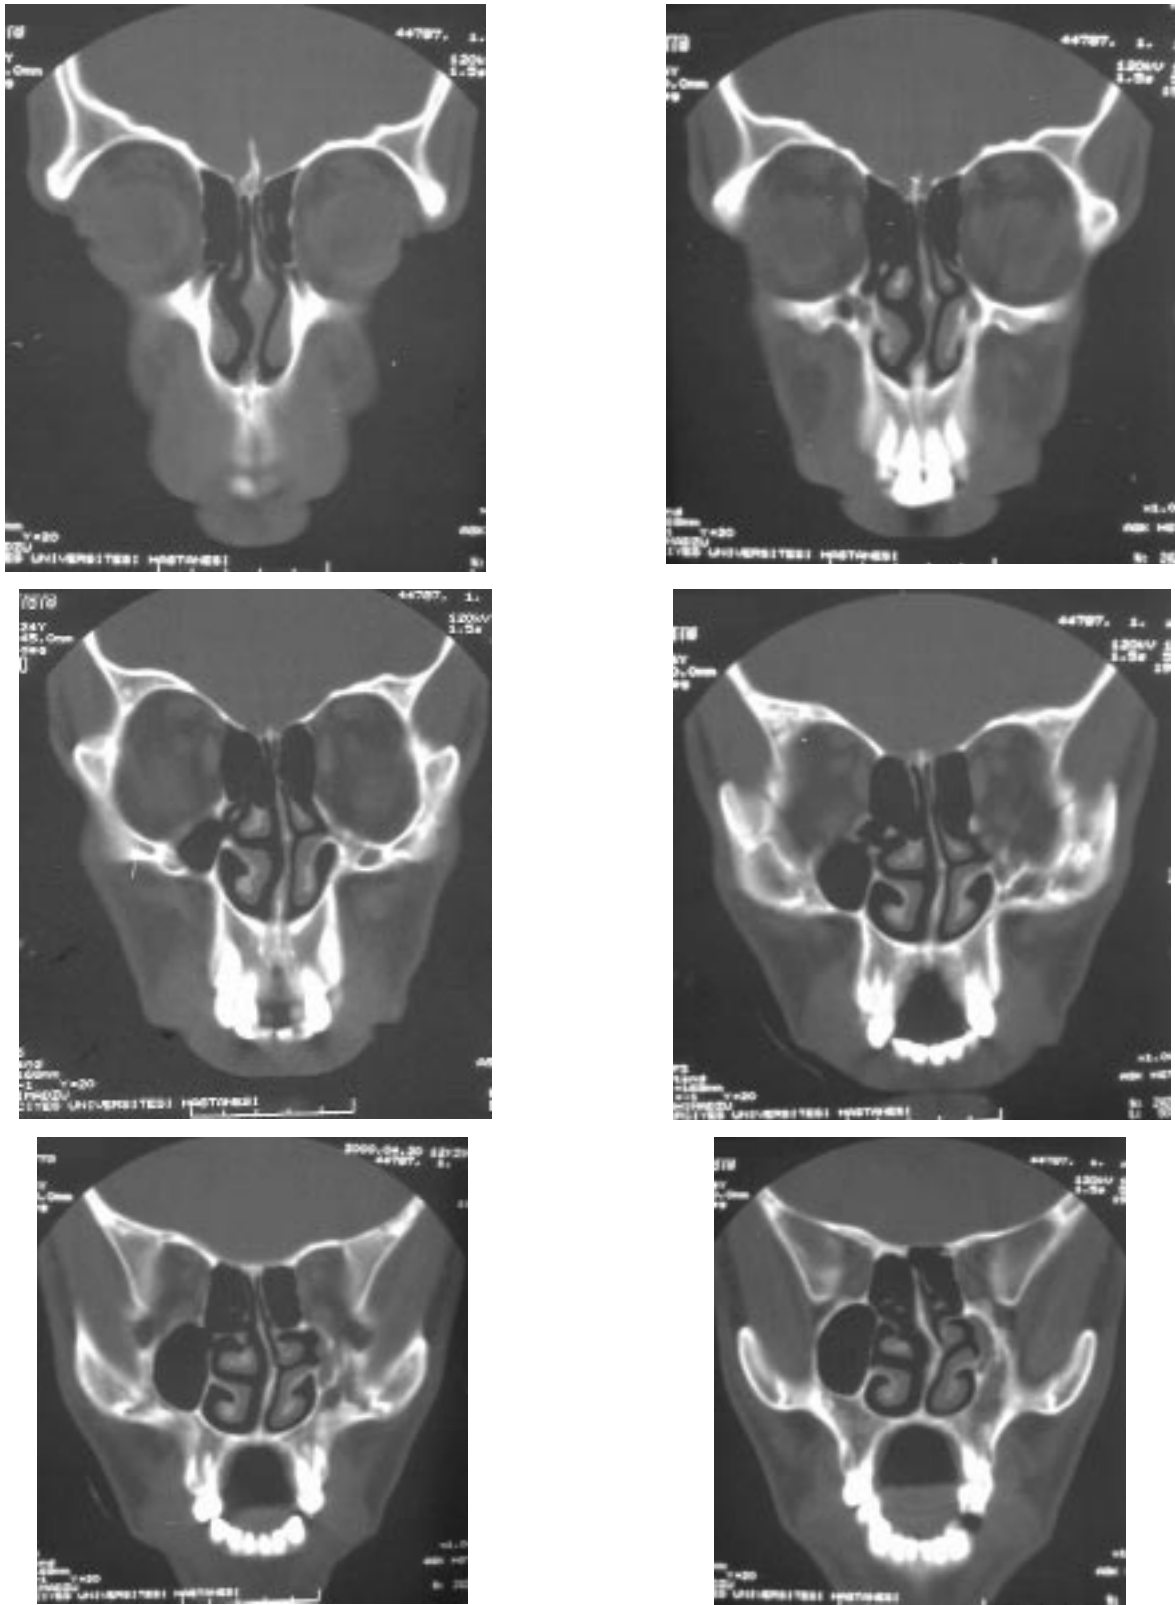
Coronal CT examination with 5 mm slice thickness showed absence of the right maxillary antrum, uncinate process, and maxillary infundibulum.
